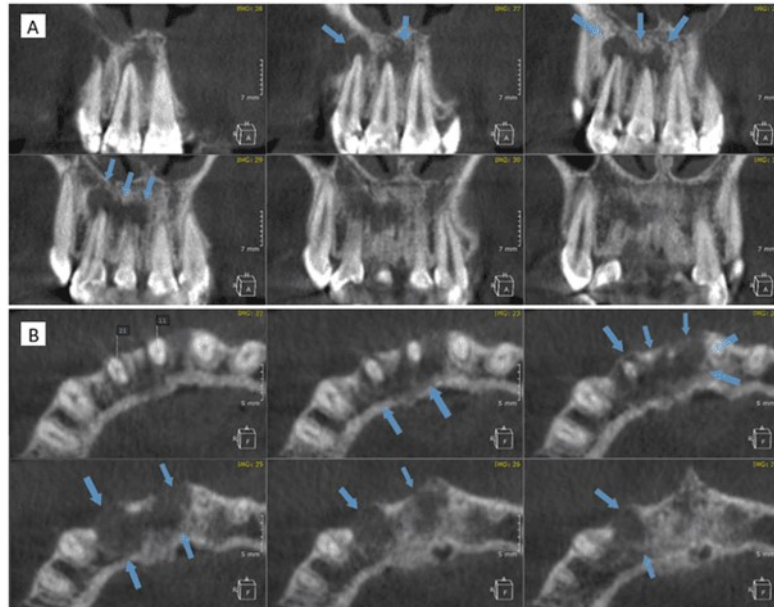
Multiplanar appraisal of the CBCT radiograph through, A) Coronal slices, and B) Axial slices. Note the transitional gradation of the lesion connection at the anterior upper maxilla region (blue arrow)
